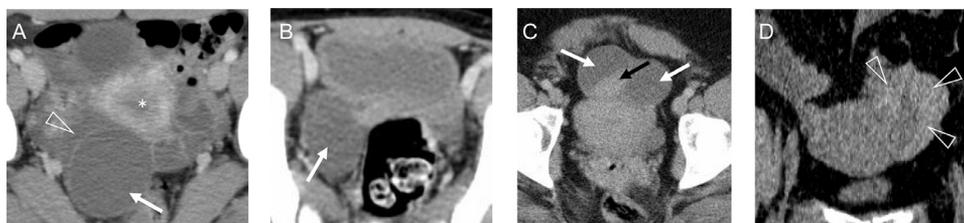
Ovarian torsion can present with an array of nonspecific imaging findings on CT and US. (A) axial CT image shows a large right ovarian cyst (arrow), the adjacent dilated fallopian tube (arrowhead), and uterine deviation (asterisk), in a patient with acute ovarian torsion. (B) axial CT image in 5-year-old with acute pelvic pain shows an enlarged ovarian cyst (arrow) and asymmetric right ovary in a patient with ovarian torsion. (C) axial CT image showing an ovary positioned anterior to the uterus with 2 cysts (arrows), one which contains layering hemorrhage (black arrow) in a patient with subacute or chronically torsed ovary. (D) coronal CT image show a patient with hematosalpinx evident by a dilated fallopian tube (arrowheads) with hyperdense fluid; hematosalpinx may be seen with ovarian torsion. Note that lack of ovarian blood flow is a specific finding for torsion but is not sensitive, and patients presenting with acute pain, an asymmetrically enlarged ovary, abnormally positioned ovary, uterine deviation, and a hemorrhagic cyst or cystic teratoma, should be clinically evaluated by GYN to assess for torsion.
